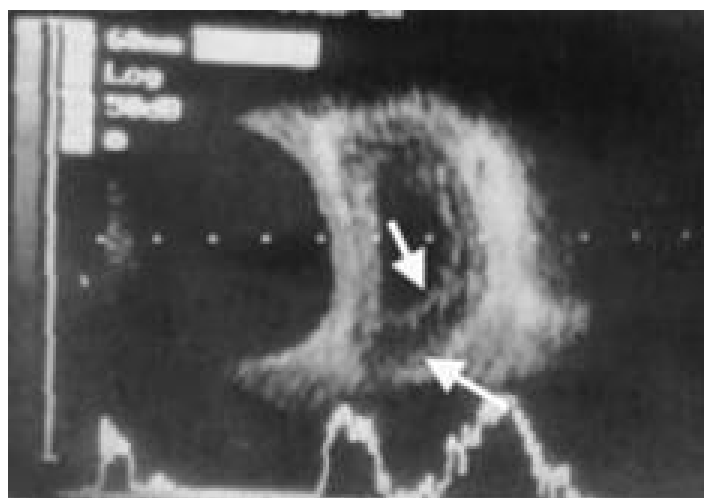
Orbital ultrasound: “double wall” sign specific of orbital hydatid cyst.
